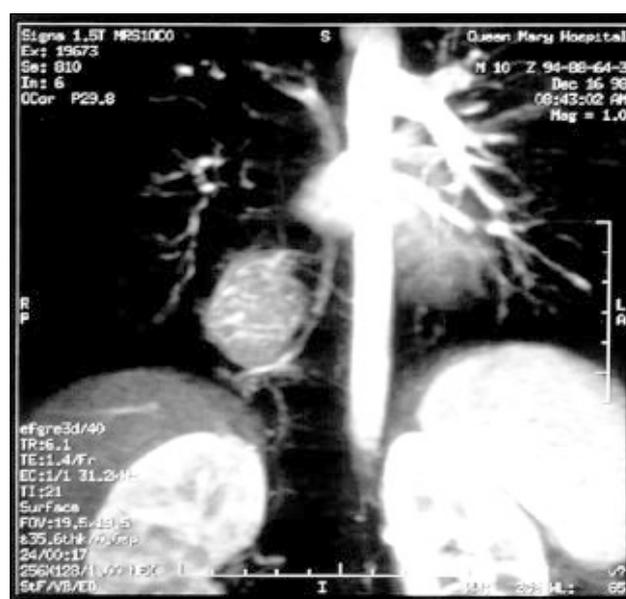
Magnetic resonance imaging of the thorax showed a hyperintense T2-weighted phaeochromocytoma measuring 4.6 x 2.5 x 4.3 cm at the right paraspinal region at level T8 to T11
